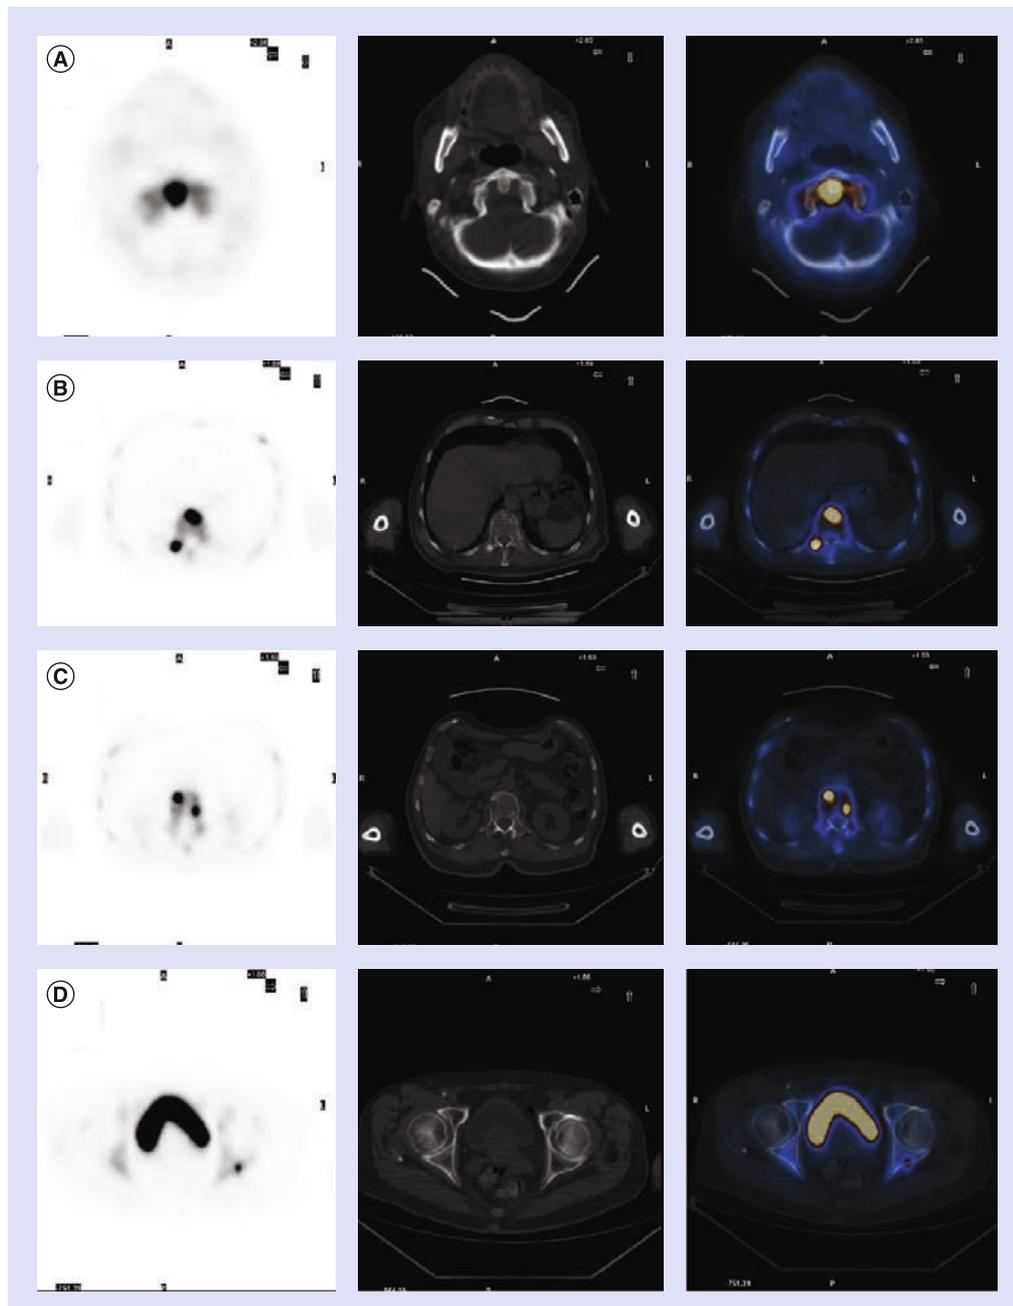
Na¹⁸F PET/CT performed in a 75-year-old male with newly diagnosed non-small-cell lung carcinoma. Transaxial Na¹⁸F PET, low-dose CT and fused images are presented in rows. (A) Blastic lesion involving the dens of epistropheum. (B) Osteolytic (anterior part of the vertebral body) and blastic (right transverse process) metastases are seen in T8. (C) Osteolytic metastasis on the right side of T12 vertebral body. Initial bone sclerotic metastasis with high Na¹⁸F uptake is seen contralaterally. (D) Small periosteal lytic metastasis in the left acetabulum.
